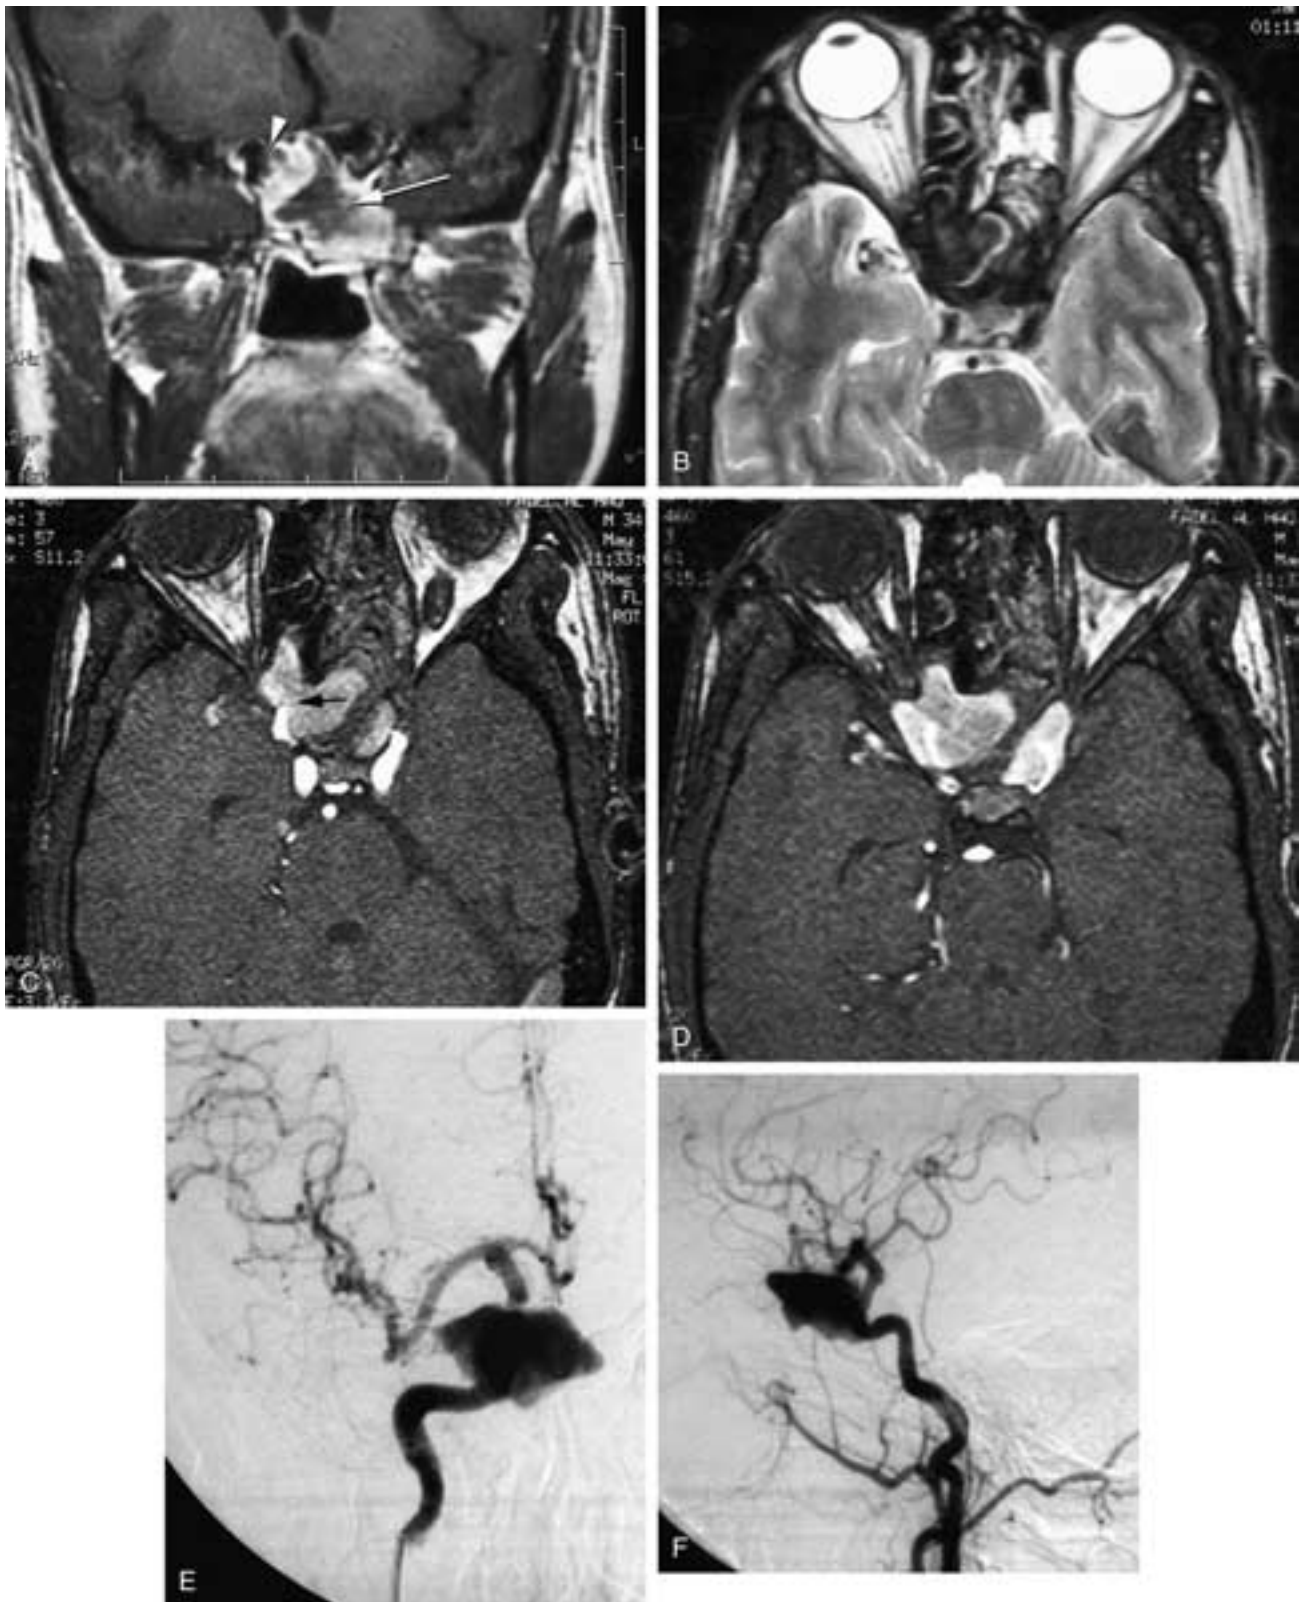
Carotid aneurysm (possible pseudoaneurysm) extending into the sphenoid sinus. A, Coronal T1-weighted image shows variable signal intensity (*arrow*) within an expanded sphenoid sinus. The enhancement along the margin might suggest mucocoele. There is slight irregularity (*arrowhead*) adjacent to the right carotid artery. B, Axial T2-weighted image shows low signal within the sphenoid. C, SPGR image shows the proximity of the carotid artery (*arrow*) to the sphenoid sinus. D, Axial SPGR image slightly cephalad to C shows the expansion of the sinus. E and F, AP and lateral internal carotid injection and lateral common carotid injection shows the aneurysm filling the sphenoid sinus. (Courtesy of Dr. Mohammad Radwan, Ibn Sina Hospital, Kuwait.)
